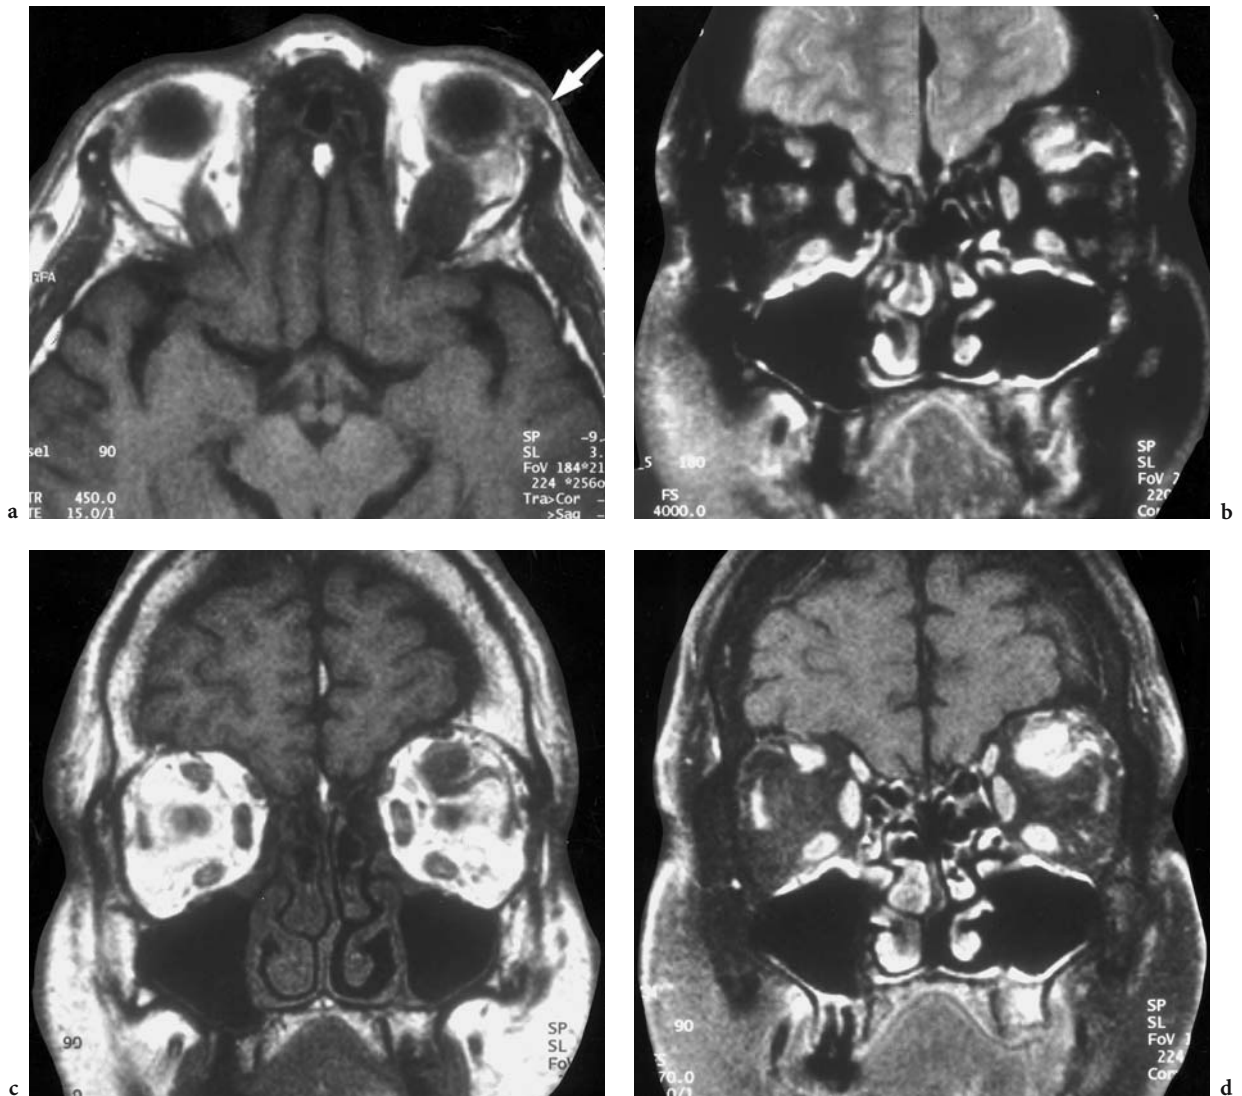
A 48-year-old man with slowly progressing, left exophthalmos suspicious for Graves' disease. Diagnosis: chronic granulomatous inflammation. MRI: a axial T1-weighted view with enlargement of the superior rectus muscle and neighboring lateral extraconal lesion, protruding towards the left lacrimal gland (*arrow*). b Coronal T2-weighted (FS) image with apparently edematous infiltration of the fascia, dividing the involved superior rectus and levator palpebrae muscle. c Corresponding T1-weighted native view. d Corresponding contrast-enhanced (FS), T1-weighted view where the signal enhancement of the infiltration is best seen between the superior rectus and levator palpebrae muscle
